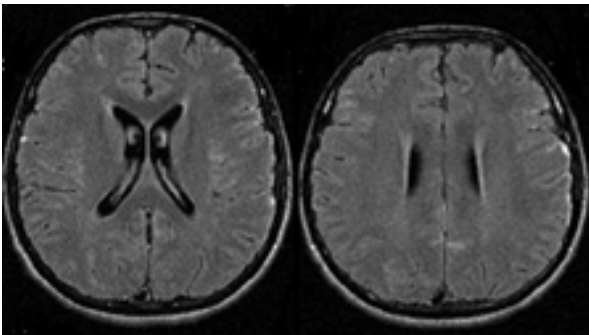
MRI Data Of Patients With Autoimmune Encephalitis.
